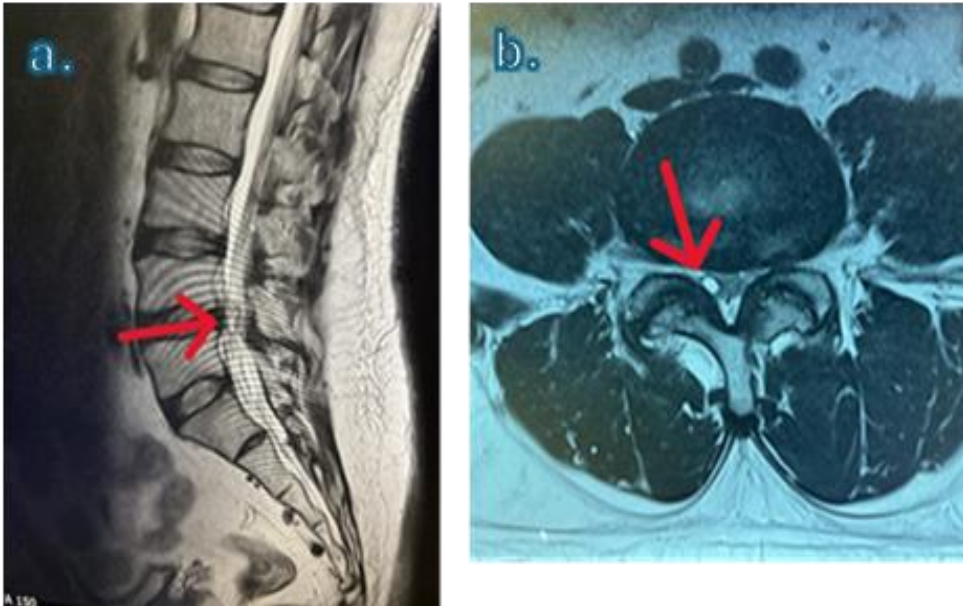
T2-weighted MRI: multilevel lumbar spondylosis most marked at L4/5 and a 4.4 x 3.3 x 15.5 mm LFSC (red arrow) arising from the anteromedial facet joint impinging upon the right L5 nerve root. (A: sagittal view. B: axial view demonstrating LFSC at L4/L5 level.)
